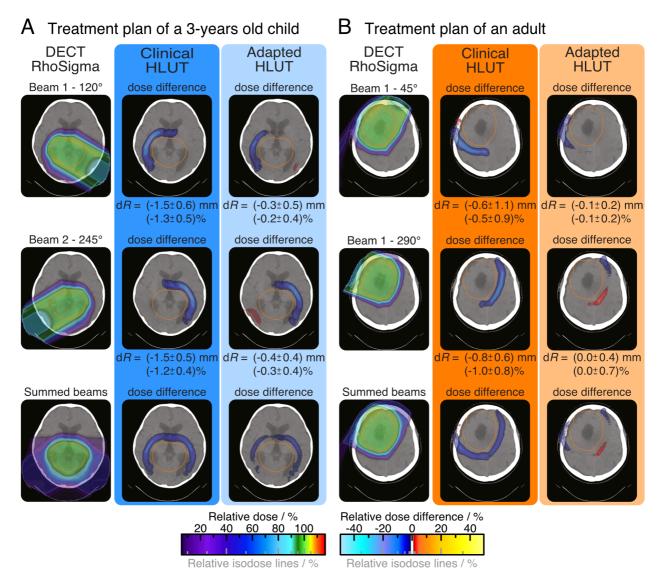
Dose difference as well as mean absolute and relative range deviation (dR) between the dual-energy CT based stopping-power prediction and clinically applied or adapted Hounsfield look-up table (HLUT) for two single treatment fields and the summed treatment plan.
